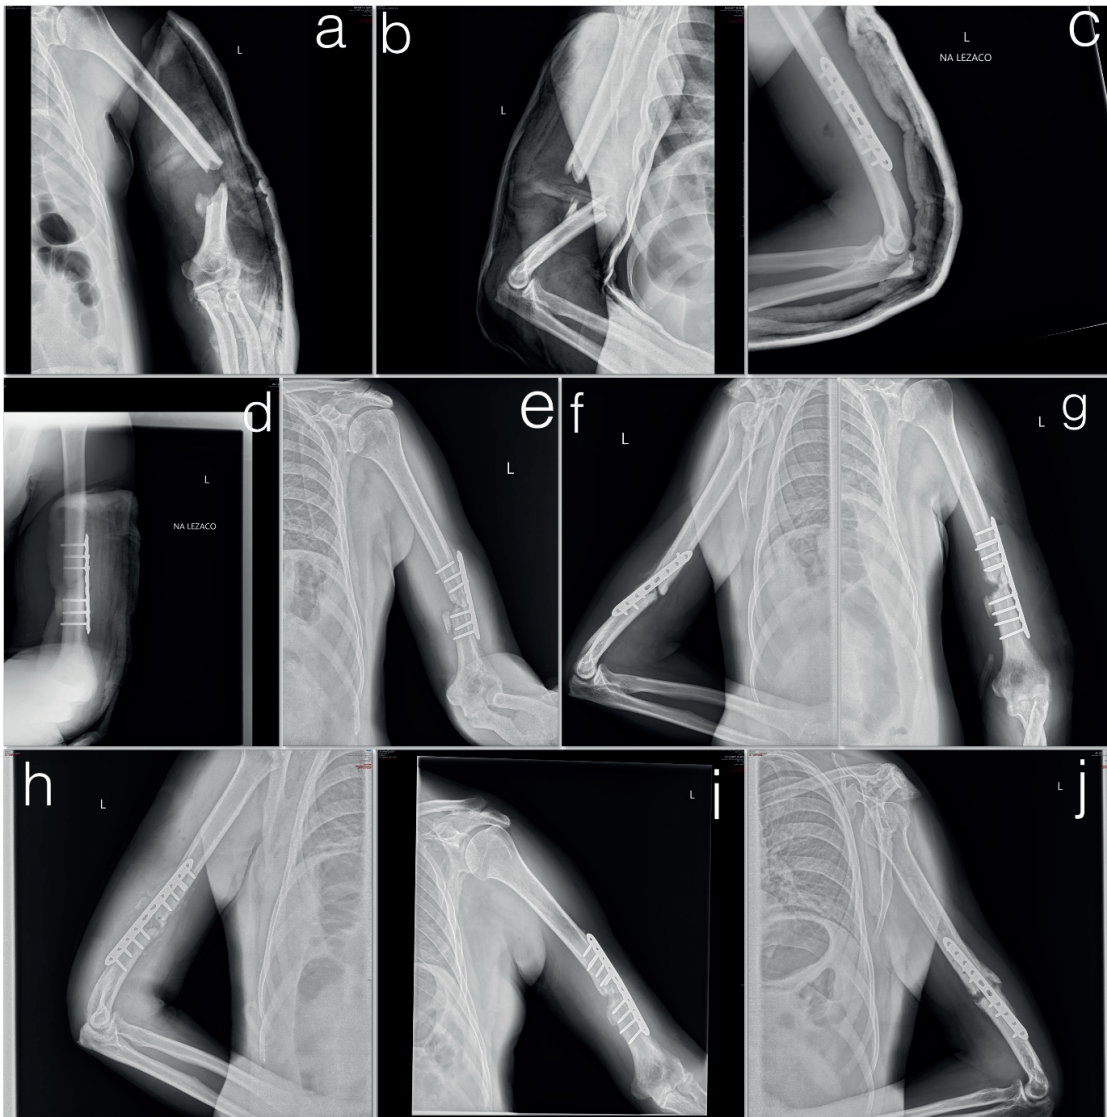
Distal 1/3 humeral shaft fracture x-rays (a,b) fixed primarily with a straight plate c and d are post-operative x-rays. Five months after initial surgery revision was made due to implant failure (e,f). Patient reoperated (g,h) and after 3.5 year since initial surgery pseudarthrosis persists with progressive angular deformation (i,j), patient does not want to reoperate.
